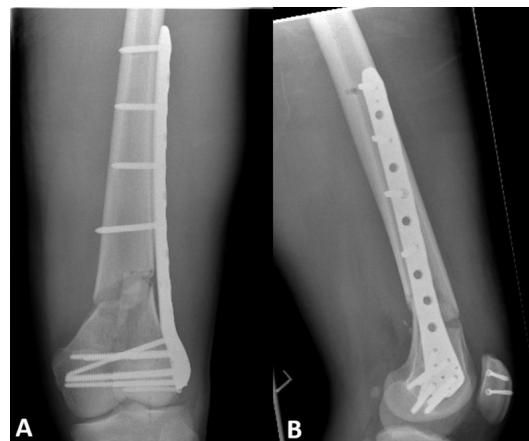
Postoperative X-rays of the left distal femur and patella. Open reduction and internal fixation of the distal femur with an anatomical plate and screws, with compression of the intra-articular fracture component and bridging of the metaphyseal fracture. Fixation of transverse patella fracture with two compression screws. (A) Anteroposterior view. (B) Lateral view.
